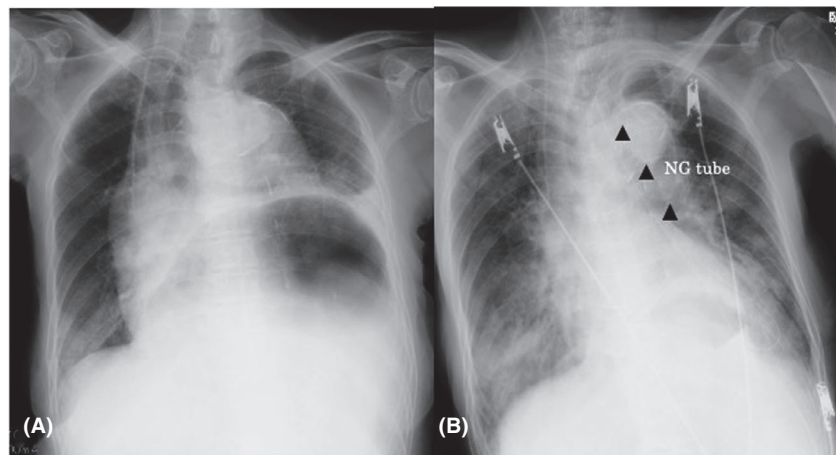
Chest radiograph showing (A) excessive gastrointestinal gas in the mediastinum or the left side of the chest cavity. A marked right-sided displacement of the mediastinal shadow is observed. In addition, a marked right-sided displacement of the trachea can be seen. (B) The expanded stomach was decompressed by the insertion of a nasogastric (NG) tube, which led to the reversal of the mediastinal displacement.
